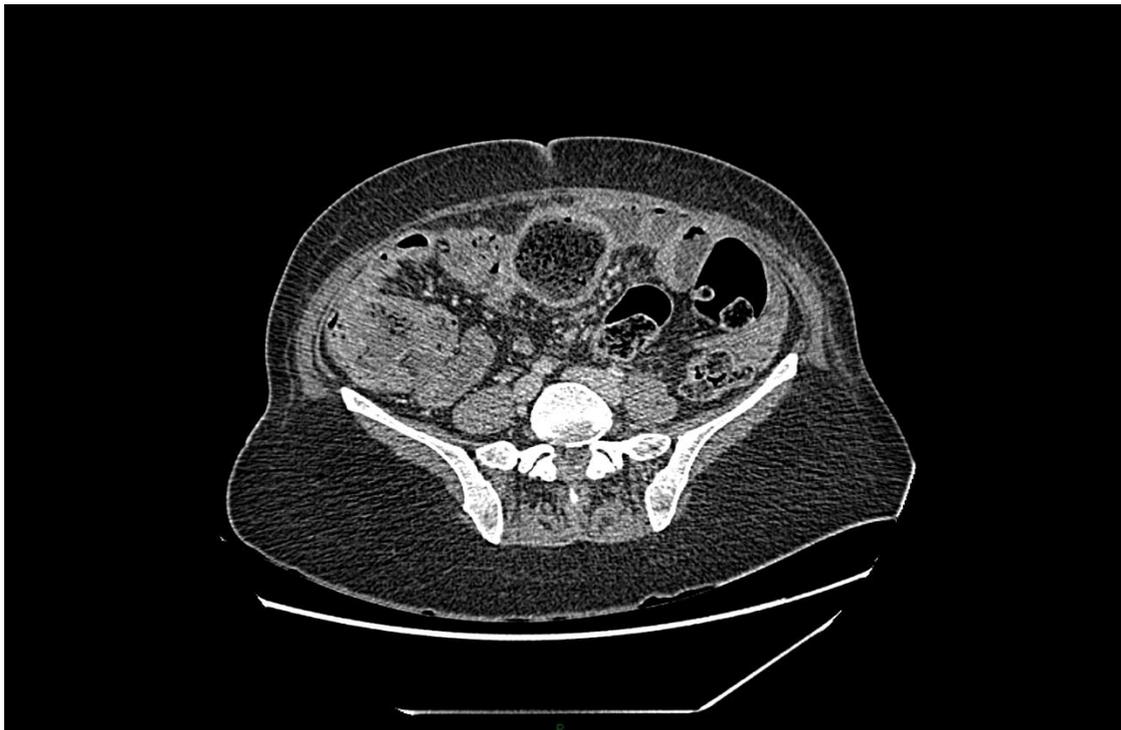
CT abdomen and pelvis revealed a 46mm, well circumscribed bezoar within the ileum, causing complete luminal obstruction with surrounding bowel oedema.
